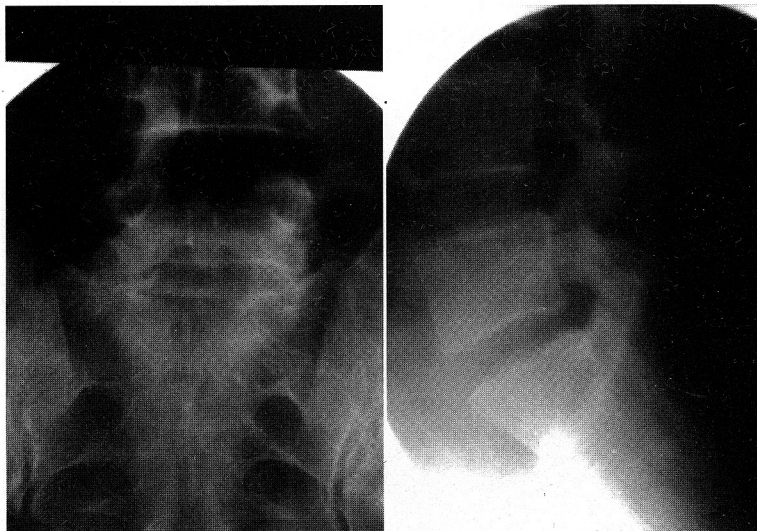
The plain roentgenograms of the lumbosacral spine show reduction of the lumbosacral fracture-dislocation.
